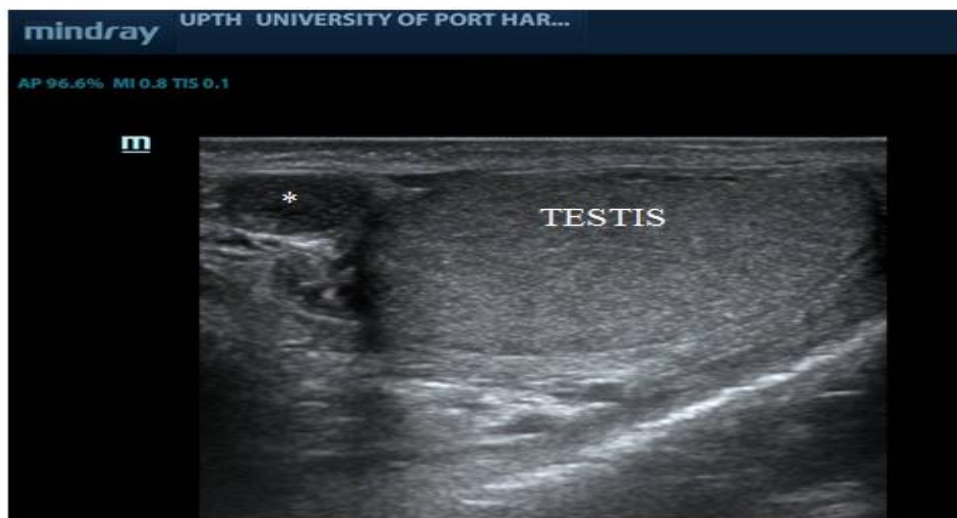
Epididymal cyst. Sonogram shows a well defined thin walled cyst (*) with fine internal echoes in the head of the epididymis
